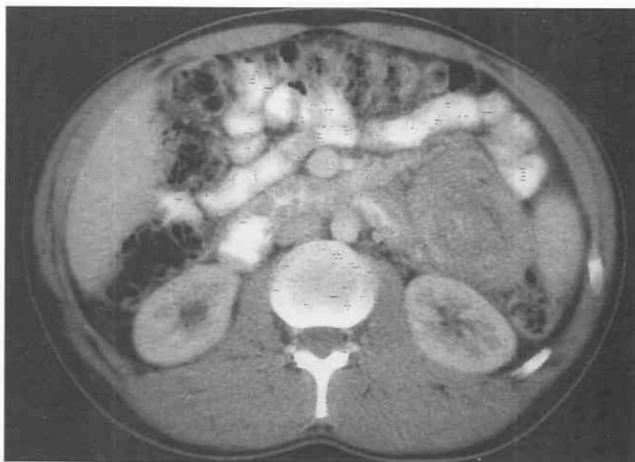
Small bowel intussusception. CT scan through the upper abdomen in a patient with lymphoma shows a small bowel intussusception.
